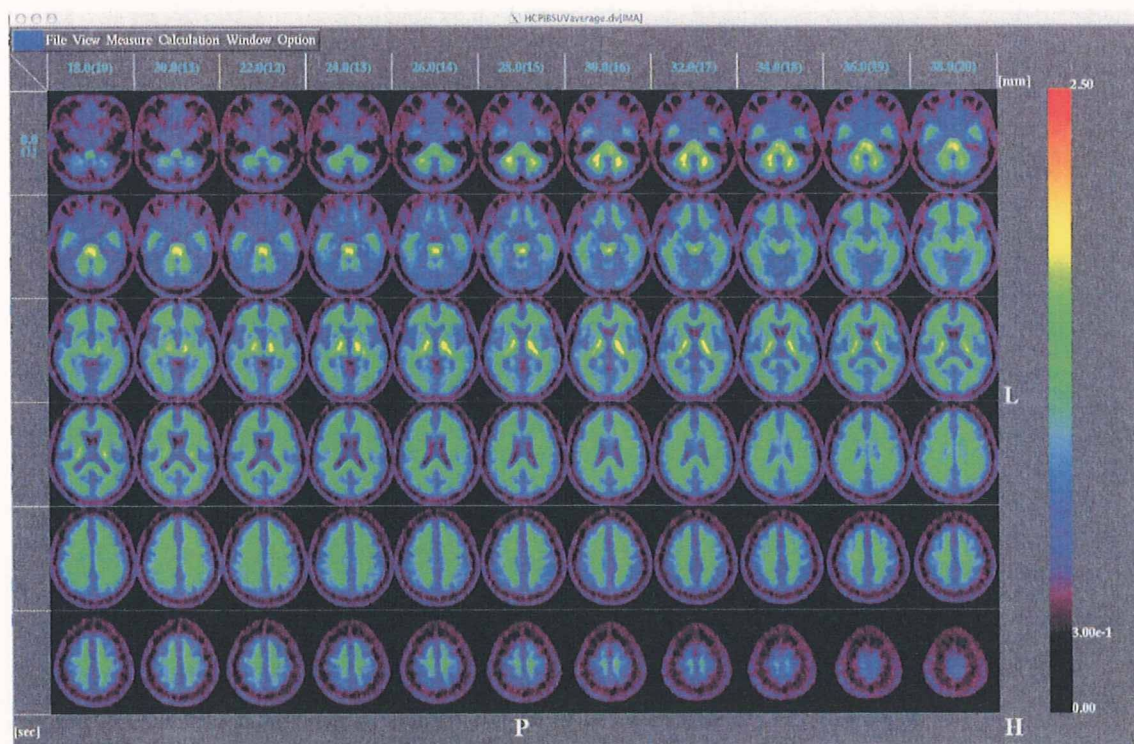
健常者におけるPiB後期SUVR画像の平均イメージ 特徴が分かりやすいように、ここでは50-70分の加算画像を小脳皮質への集積で基準化し、7名分を平均した画像を示す。白質に比較的均一な集積があり、これを基準にしてみると、大脳皮質、小脳皮質への集積は、白質よりも低いレベルにあることが分かる。また、視床、脳幹部（特に橋底部）、小脳髄質への集積は、大脳白質よりもやや高い。健常人でも前頭葉の灰白質は他部位の灰白質に比べ集積はやや高めで、画像の分解能によっては白質よりも灰白質への集積が低いことが分かりにくい傾向があるが、皮質の辺縁に至るまで、白質と同等あるいはそれ以上の集積が1脳回を越えた広がりを持って明瞭に存在しなければ、集積疑いあるいは陽性とは判定しない。
